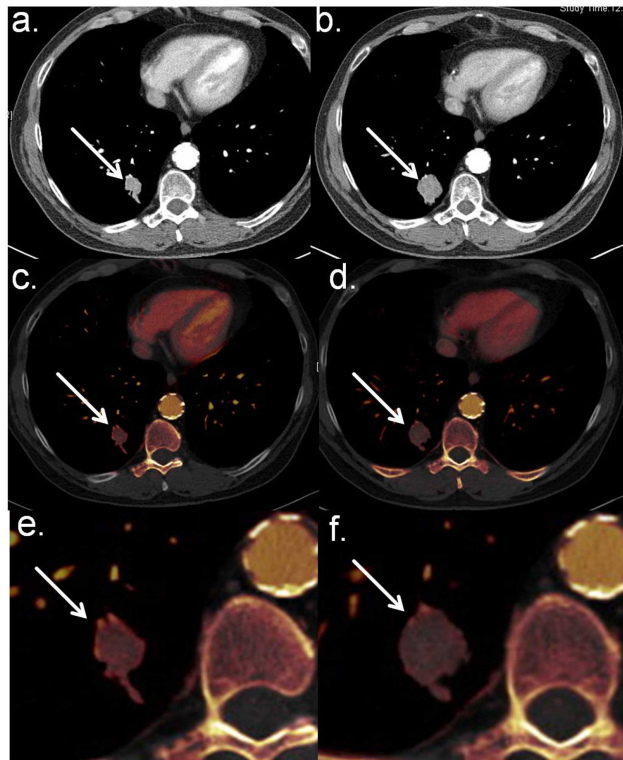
Pulmonary metastases examined before and after first cycle of chemotherapy using dual-energy computed tomography. Minor reduction in size and reduction of contrast-medium uptake in the course of time.
